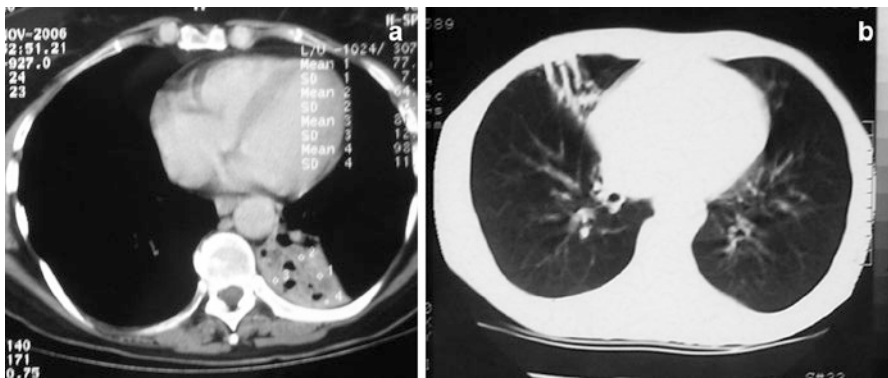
Lesion is localized behind the heart—diagnosis is obtained by CT
